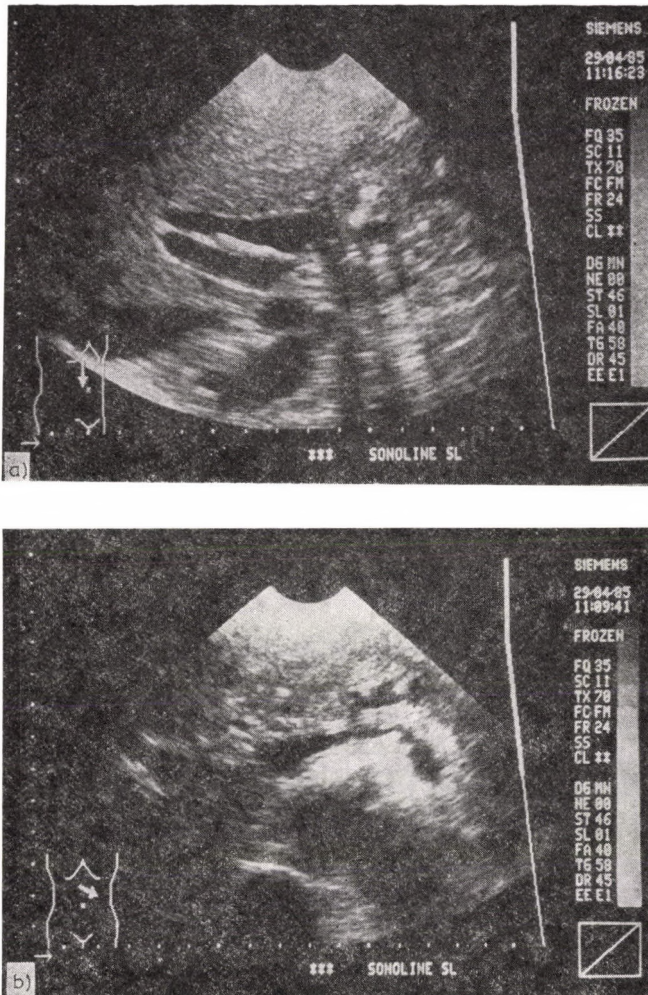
Sonographic scan of MJ., a male patient, aged 53, characteristic of chronic pancreatitis. A. The pancreas is enlarged, inhomogeneous, with calcification in the parenchyma. The bile duct is dilated, the liver is homogeneous in structure. B. The pancreatic duct is dilated, visualized along a long segment and of a tortuous course, containing stones
